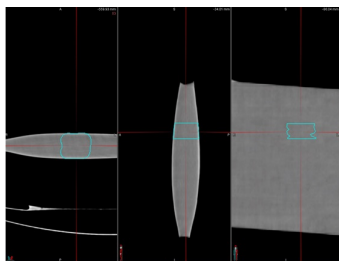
CT scan of a cuboid ($150 \times 150 \times 10 \text{ mm}^3$) filled with gelatine. Left to right: top view, side view and front view.
